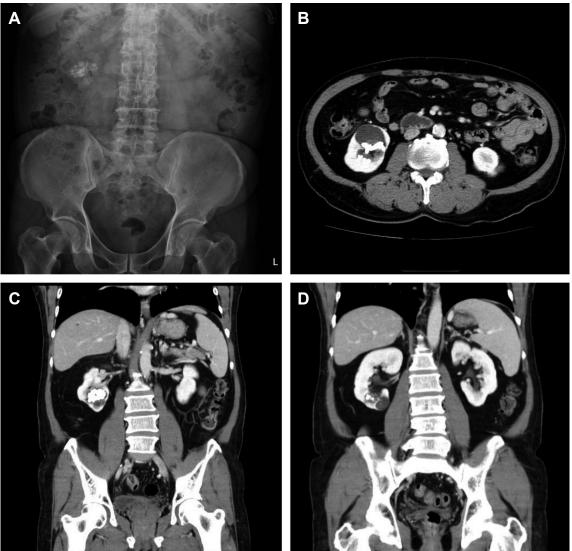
Pre-operative plain abdominal radiograph and a contrast-enhanced abdominal computed tomography scan revealing a cluster of cystic lesions with nodular calcifications over right renal lower anterior pole with delayed contrast filling. (B) The largest diverticulum with thin overlying parenchyma. (C,D) The other two diverticula buried in renal parenchyma at a distance of 0.7 cm and 0.5 cm, respectively, from the surface of parenchyma. All three diverticula could not be presented in a single cross-sectional image.
